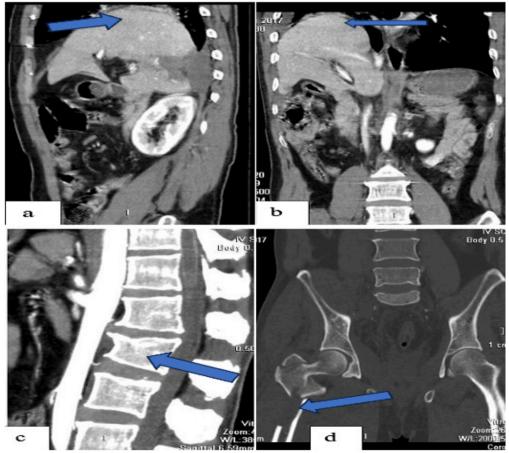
(a) Sagittal CT image(a) of abdomen and pelvis showing waist like diaphragmatic defect (arrow) with herniation of liver into the thoracic cavity. Coronal CT image (b) of abdomen and pelvis showing the herniation of liver into the thoracic cavity (b). Sagittal CT image (c) of vertebra showing compression fracture of L2 vertebra. Coronal CT image (d) of pelvis showing right intertrochanteric fracture extending into the shaft of femur (d).
